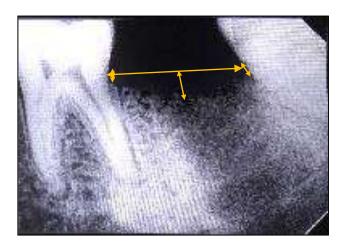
Height of bone- Immediate post operative radiograph with Arrows showing Central, mesial and distal linear measurements
